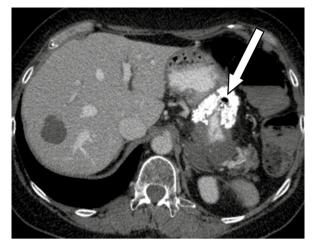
Computed tomography image of the abdomen showing a partially calcified tumor, with signs of decay in the central section. Visible fistula canal to the gastric lumen (arrow)
